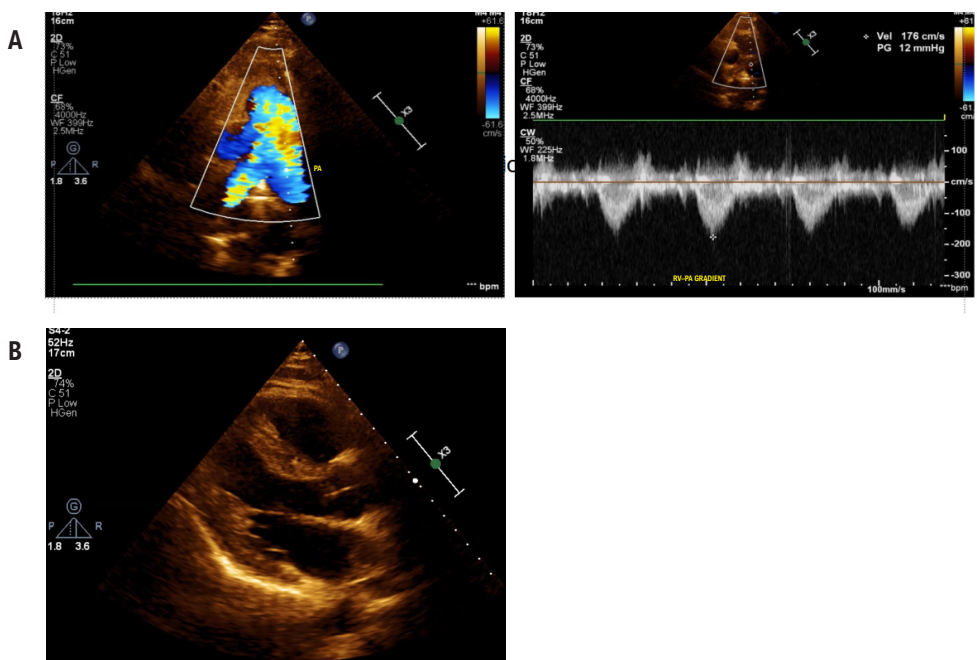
A) Maximum pulmonary valve gradient of 12 mmHg. B) Parasternal long-axis view, showing absence of the mass after treatment. PA: pulmonary artery; RV: right ventricle.
